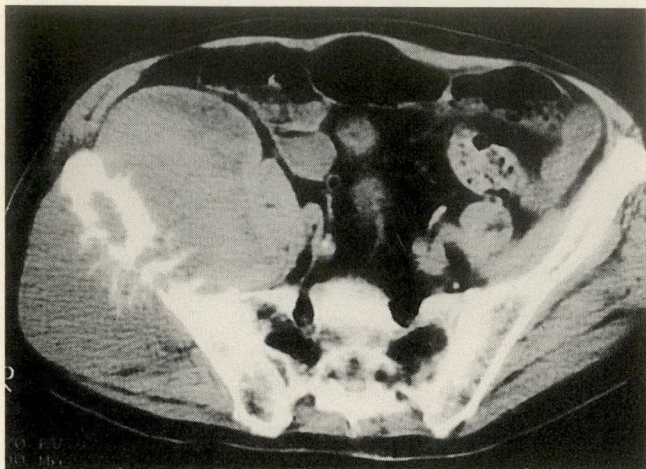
Computed tomography (CT) scan of pelvis at presentation.
